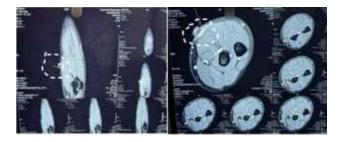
Image on left coronal. On right Axial view of MRI showing location of mass in the Proximal
